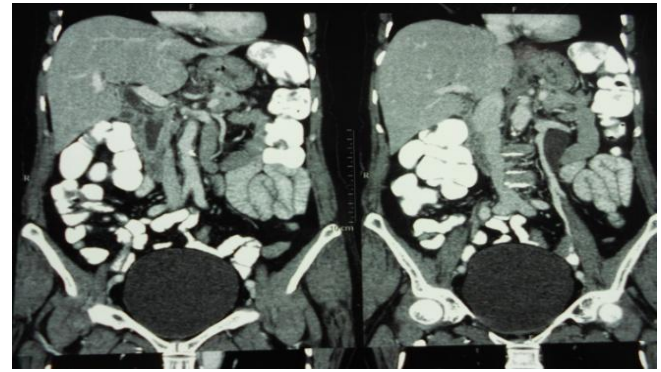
CT scan showing bulky pancreas with minimally enhancing mass lesion measuring approximately 7mms near ampulla of vater causing obstruction of both CBD and pancreatic duct
